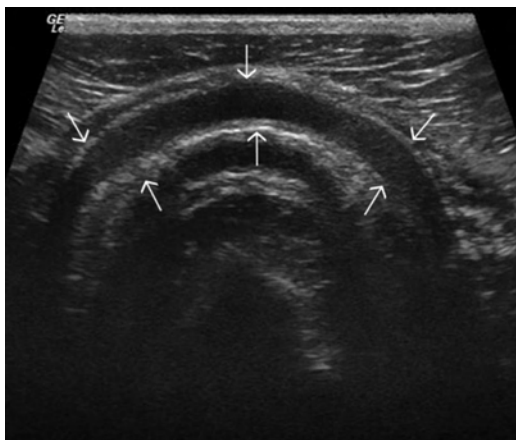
Transverse plane ultrasound image of the ventral aspect of the cricoid cartilage (arrows) of a normal larynx. Left is to the left of the image and right is to the right of the image.
